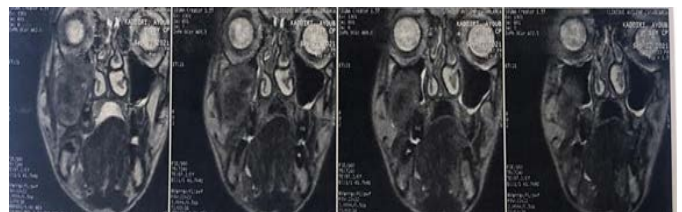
MRI on coronal section showing the tumor that comes into contact the floor of the orbit.
